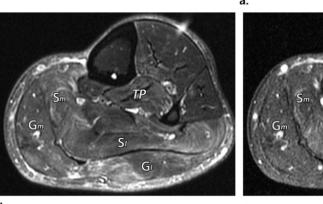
Chronic IBM in a 60-year-old man with a 5-year history of bilateral lower extremity weakness and elevated creatine phosphokinase levels. MR imaging was performed to guide biopsy. Axial T1-weighted (a), STIR (b), and postcontrast T1-weighted fat-suppressed (c) MR images of the proximal calf show complete fatty atrophy of the medial head of the gastrocnemius (G_m) and medial aspect of the soleus (S_m) muscles, indicating chronic involvement. There is moderate fatty atrophy, edema, and enhancement of the lateral head of the gastrocnemius (G_p) , and to a lesser degree, the lateral aspect of the soleus (S_p) and tibialis posterior (TP) muscles. In the distal half of the calf (not shown), there is mild fatty atrophy, edema, and enhancement of the anterior compartment muscles. Similar findings are seen in the contralateral leg (not shown). The anterior compartment muscles of the leg were targeted as an optimal site for biopsy with the highest potential diagnostic yield, given the presence of muscle edema, enhancement, and lack of significant muscle atrophy. The biopsy results helped confirm IBM.
